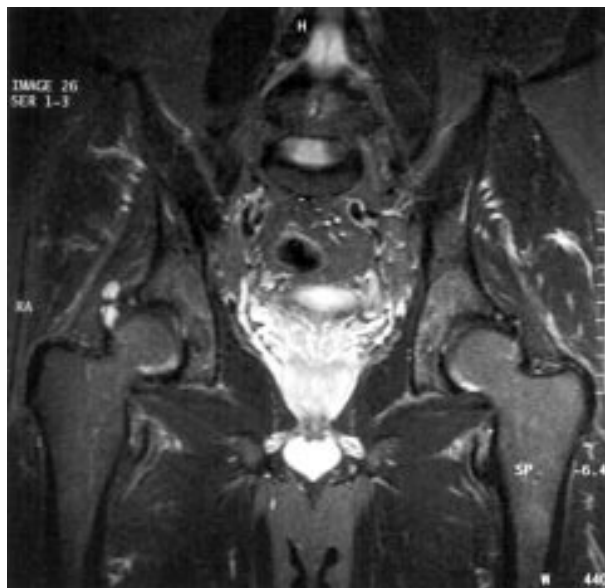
MRI showing a bilobed 2 cm “collar-stud” cystic lesion.
